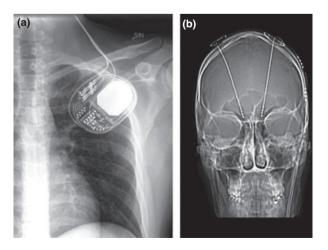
Postoperative X-ray demonstrating the implantable pulse generator (a), extension cables and DBS electrodes (b).
